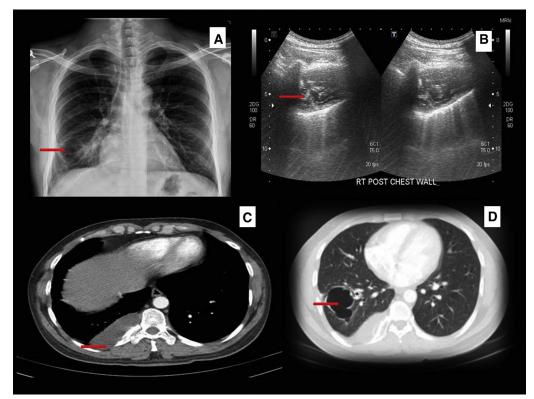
A, Chest x-ray showing an empty cavity in the right lower lobe of the lung (*arrow*). B, Ultrasonogram demonstrating the membranes of the hydatid cyst (*arrow*). C, Contrast-enhanced computed tomography of the thorax, axial view, demonstrating the necessitans (*arrow*). D, Contrast-enhanced computed tomography of the thorax, axial view, showing an empty pericyst in the lower lobe of the lung.
